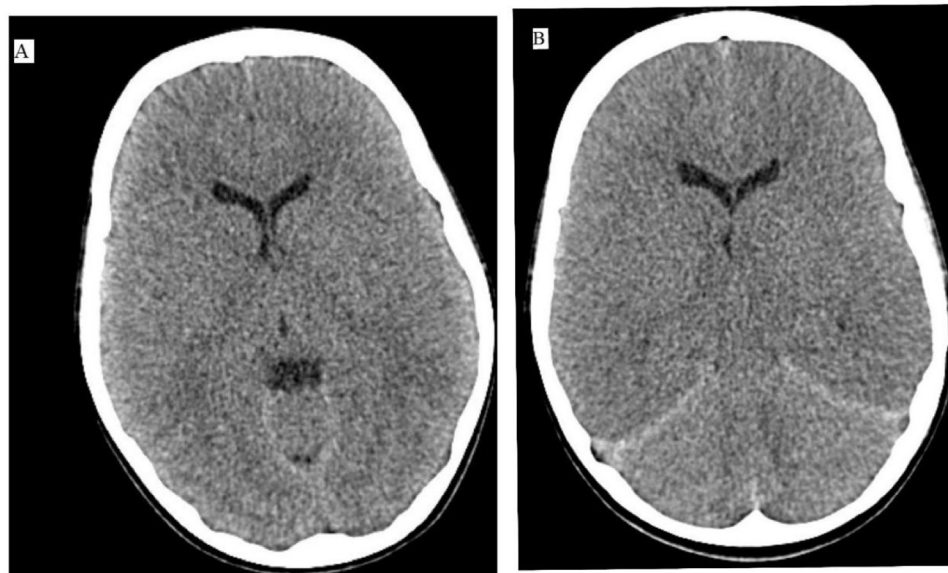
Computed tomography (CT) of the brain on day of admission (A) and three days later (B). A: Normal CT of the brain on day of admission. B: CT of the brain three days later showing diffuse cerebral edema with effacement of cerebral sulci and poor grey/white matter differentiation. Additionally, the lateral and third ventricles appear smaller and the quadrigeminal and ambient cistern are obliterated features consistent with diffuse hypoxic brain injury.
